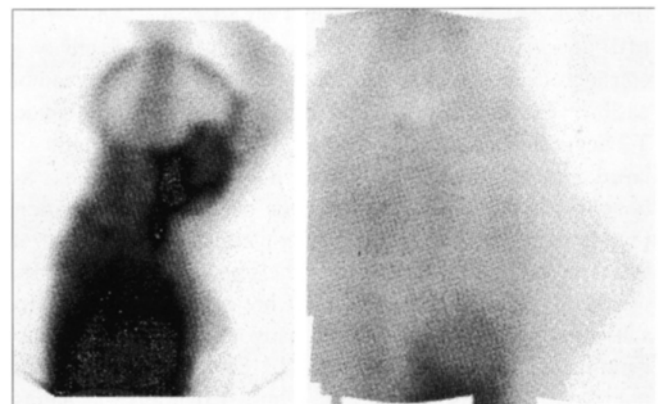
Normal sestamibi breast imaging. (A) Without a specialized table, the patient was placed on the edge of a SPECT table. Normal distribution of sestamibi is seen throughout the liver and salivary glands. This positioning was both precarious and uncomfortable for the patient. (B) Using a table overlay and adding zoom excluded the liver and head from the field of view. Normal breast tissue has very little sestamibi uptake relative to the liver and heart.
